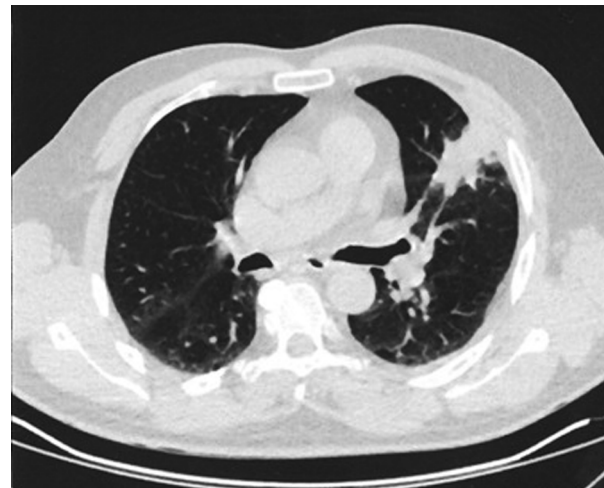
Lung CT scan images showing a mass lesion with irregular contours with extensive pleural deployment and bronchial involvement.
